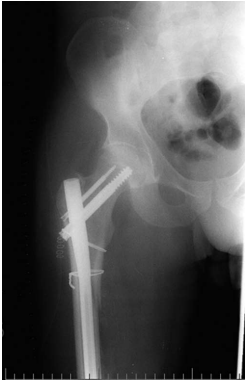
Anteroposterior radiograph of the pelvis post revision fixation.
